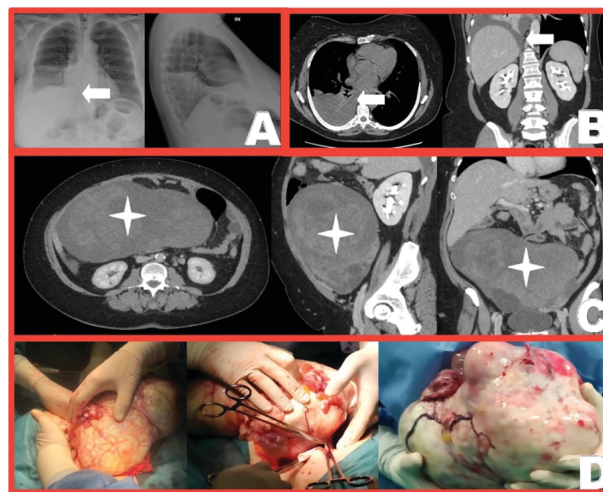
(A) Chest radiography demonstrated a right hydrothorax. (B) A CT scan confirmed the right pleural effusion, with atelectasis. (C) CT scan detected an adnexal mass of 26 × 14 × 19 cm. (D) Surgical images of left mass resulted in a fibroma of 3304 g.
